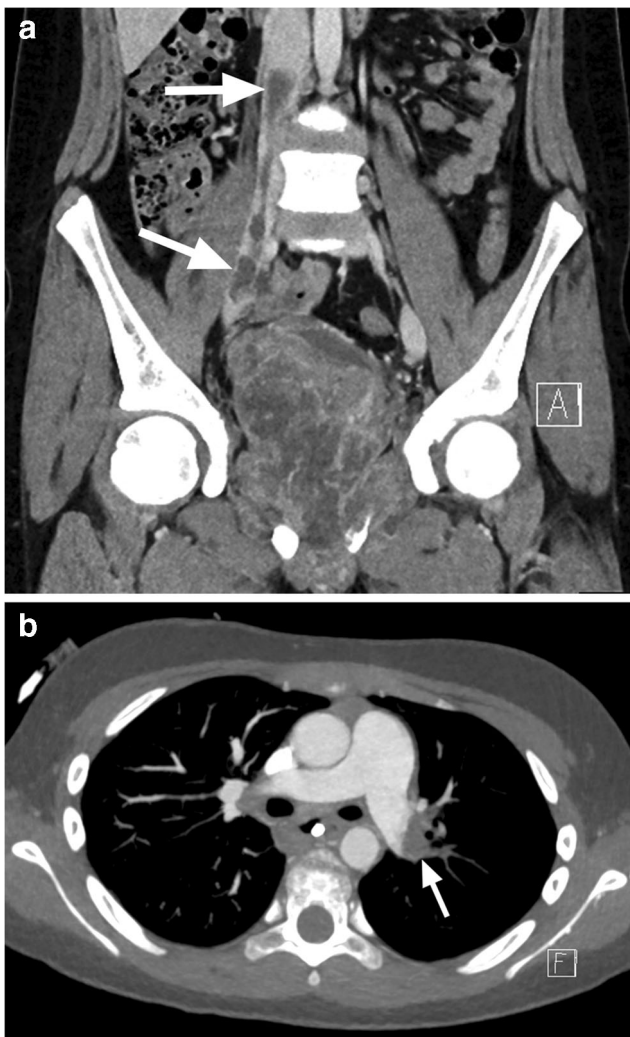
A 13-year-old boy with undifferentiated sarcoma. a Contrast-enhanced CT shows a large pelvic tumor with an intravascular tumor extending into the inferior vena cava (IVC, *arrows*). No IVC filter was placed at diagnosis. b Twelve days later, the patient developed chest pain and dyspnea, with circulatory collapse. CT shows a tumor embolus occluding the bifurcation of the left pulmonary artery (*arrow*). This was removed at emergency pulmonary embolectomy
